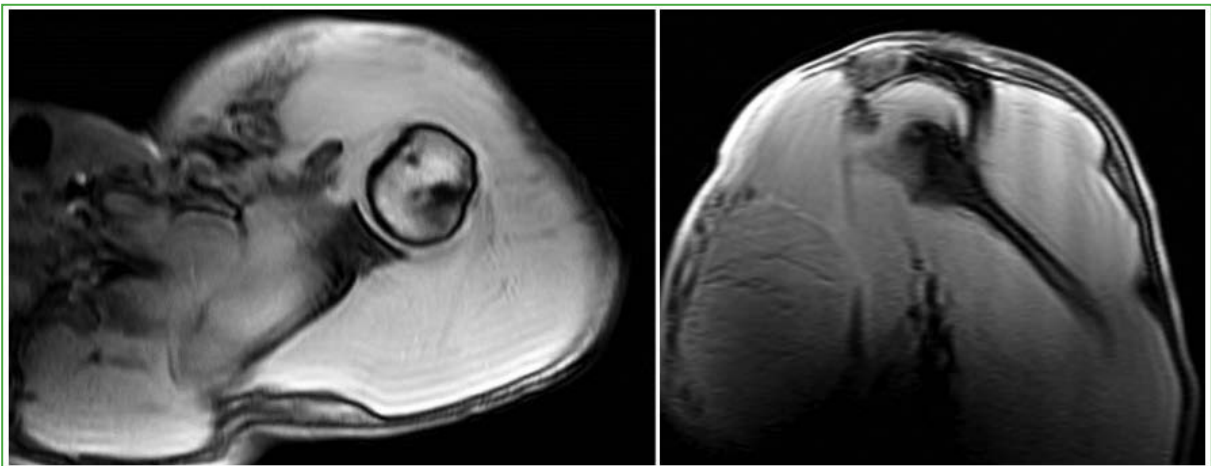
Axial MRI of the shoulder showing an extensive deep fluid collection between the pectoralis major and minor muscles, corresponding to a hematoma measuring approximately 12 x 33 mm.
